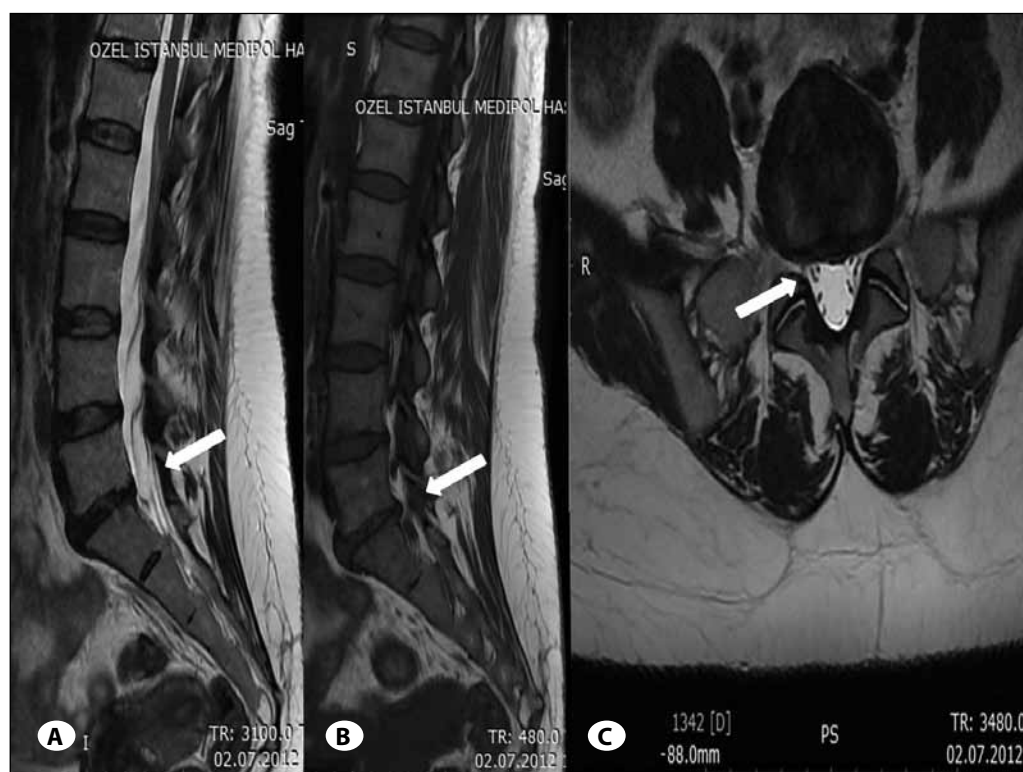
A) T2 weighted sagittal, B) T1 weighted sagittal, C) T2 weighted axial MR images show regression of extruded disc herniation at L5-S1 level (July 2012).
